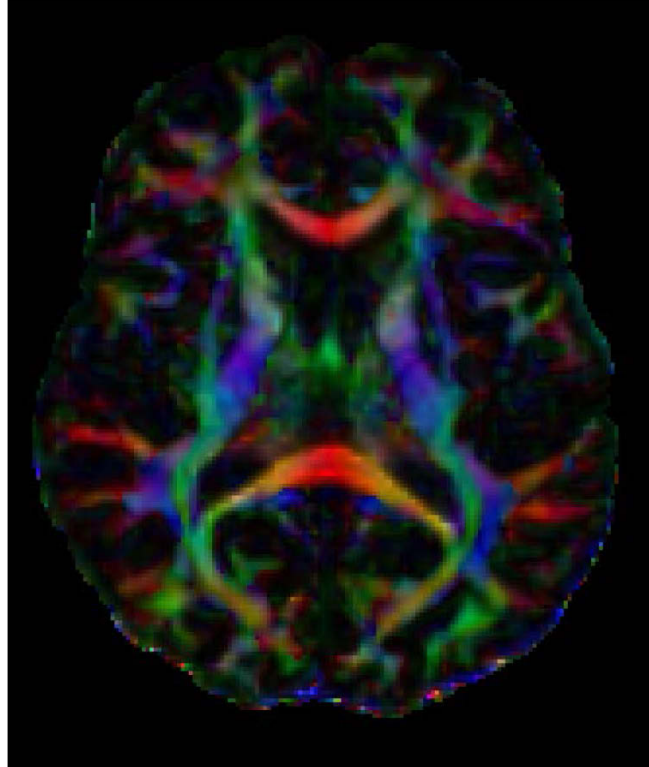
Fiber Assignment by Continuous Tracking (FACT).* Reprinted from “Three-dimensional tracking of axonal projections in the brain by magnetic resonance imaging” by S. Mori et al., 1999, *Annals of Neurology* 45(2), page 266. Copyright 2001 by John Wiley and Sons. Reprinted with permission.
